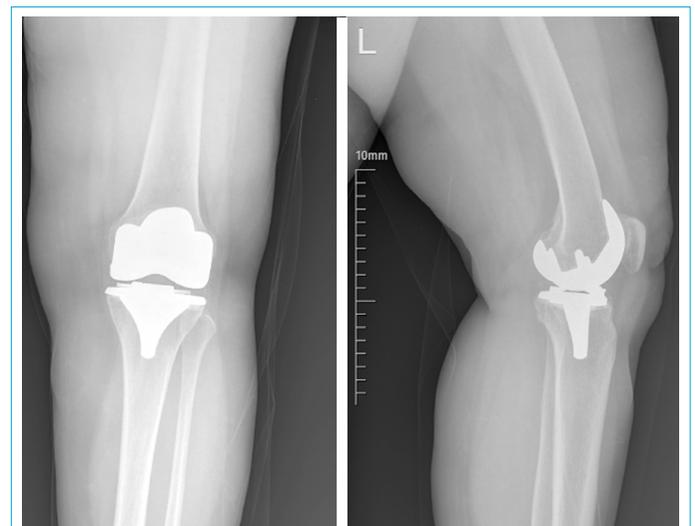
Prosthesis control with anteroposterior and lateral knee radiographs.
